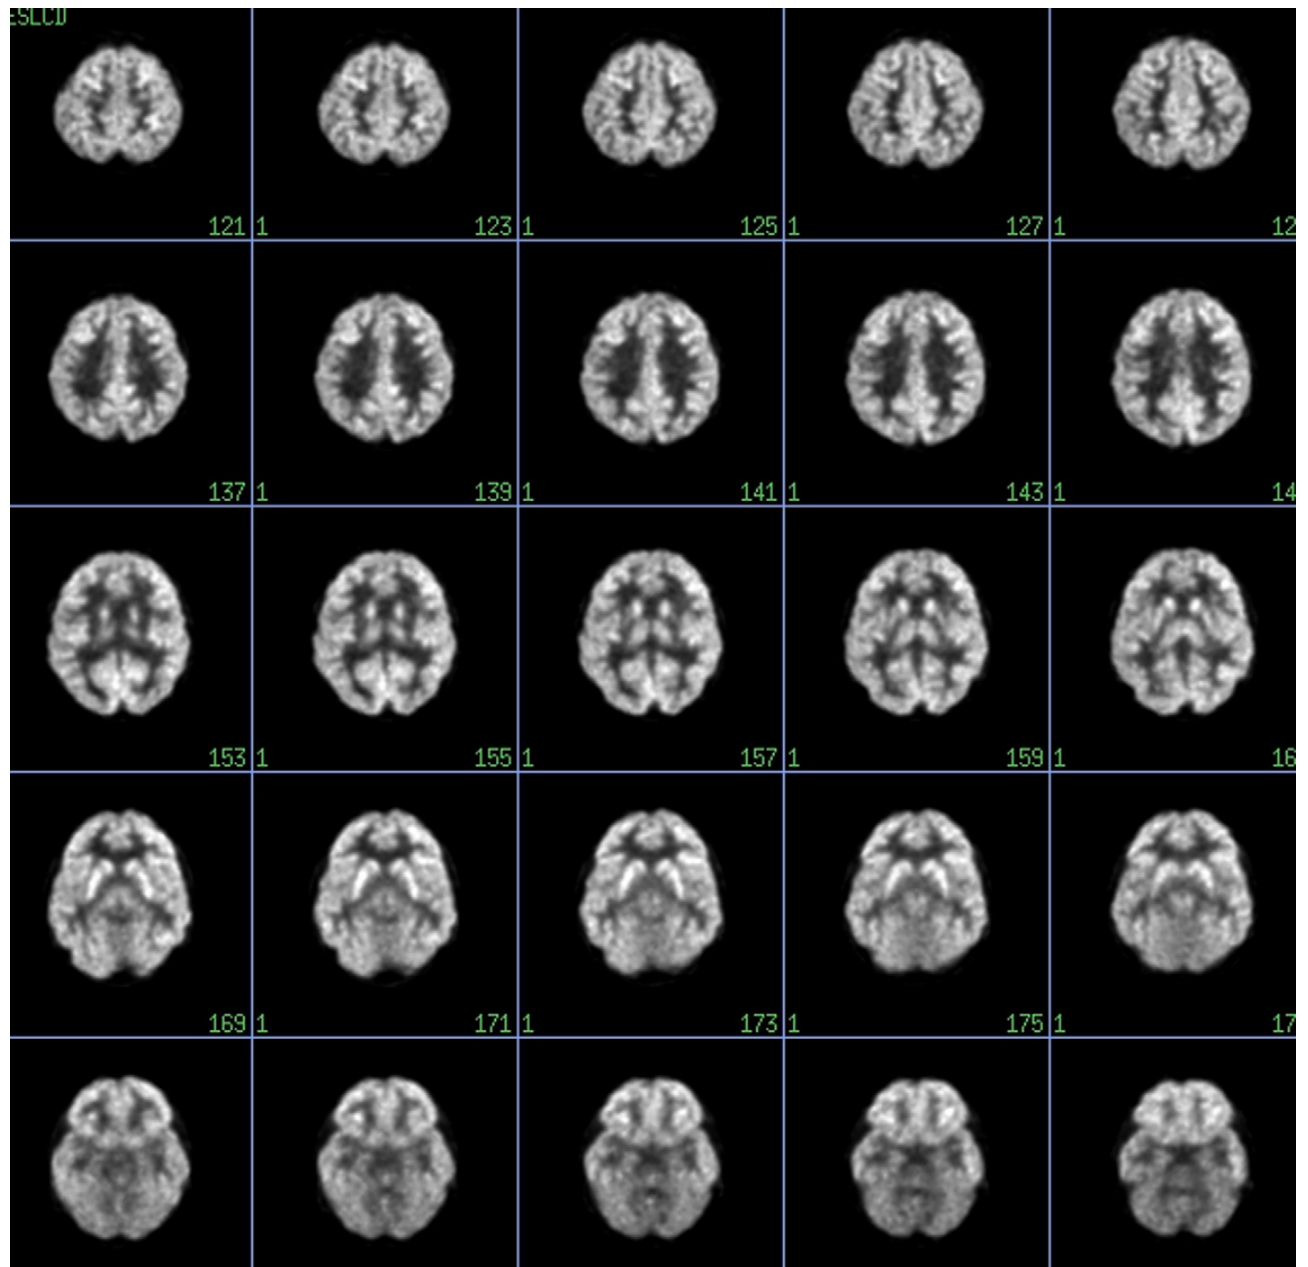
Normal FDG-PET scan from a healthy individual without any neuropsychiatric disorder. There is uniform distribution of metabolism throughout the cortical and subcortical structures.
